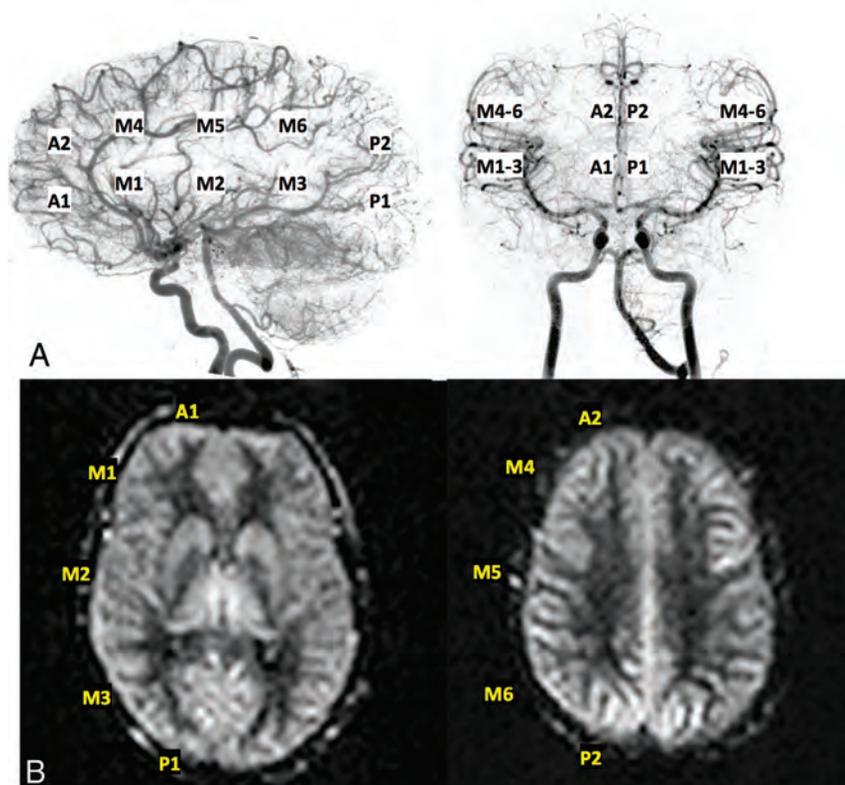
Representative ASPECTS regions used for scoring of both DSA (A) and ASL data (B); specifically, 2 ACA regions, 6 MCA regions, and 2 posterior cerebral artery regions per side were evaluated.
